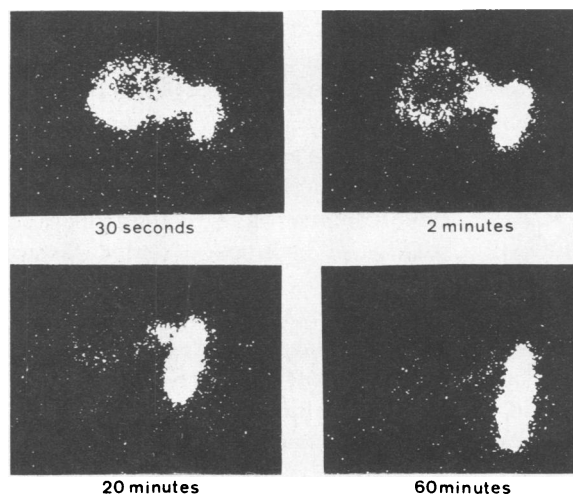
Technetium-99 microscintigraphy in a normal subject. (Compliments of Dr. D. M. Maurice)
